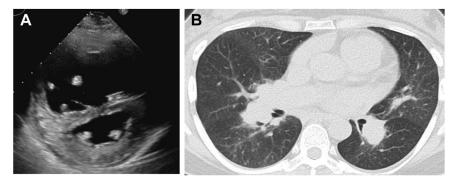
Imaging studies. (A) Transthoracic echocardiography image showing an enlarged right ventricle and a ventricular septum displaced toward the left ventricle. (B) Chest computed tomography scan showing mosaic ground-glass opacities around the bronchi, consistent with eosinophilic lung disease.
